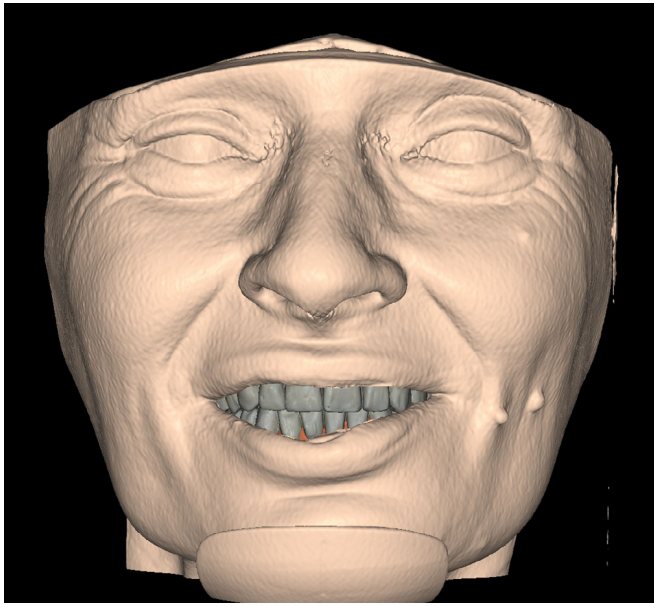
Smiling scan technique with digital wax-up. The cone beam computed tomography scan was taken with wax rims in the patient mouth to restore the centric relation and the skeletal relationship between the jaws
